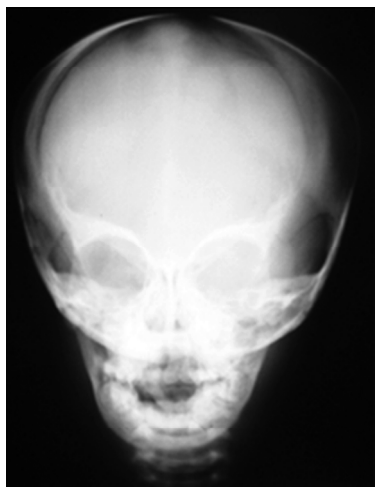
Postero-anterior skull radiography revealing generalized sclerosis of the skeleton, more pronounced in the periorbital region ("Harlequin appearance" or "Raccoon mask" sign), open fontanelles and cranial sutures, absence of facial sinuses
